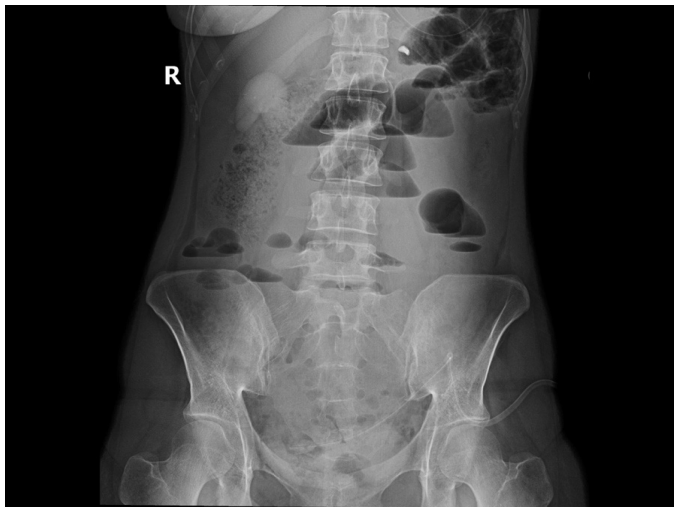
Plain Abdominal X-ray
